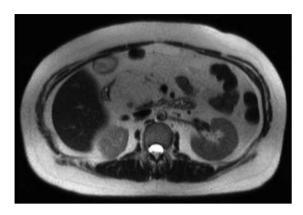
T2 magnetic resonance image. This cross sectional image reveals a 6.8 cm x 4.4 cm fat containing lesion arising from the pancreatic head, scalloping the pancreatic head and displacing the duodenum.
